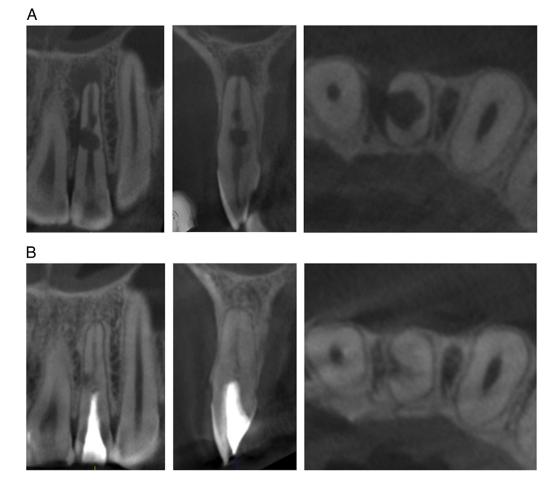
CBCT images (*A*) before and (*B*) 3 years after treatment in the frontal, sagittal, and axial reconstruction planes. The radiolucencies are healed radiographically, and the resorption cavity is filled with mineralized tissue without progression of the resorption.
